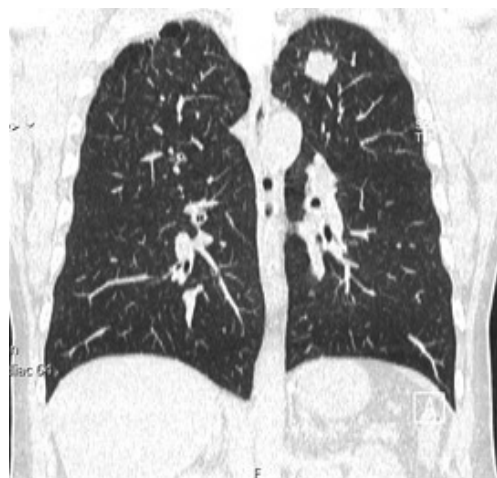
Thoracic CT scan.
